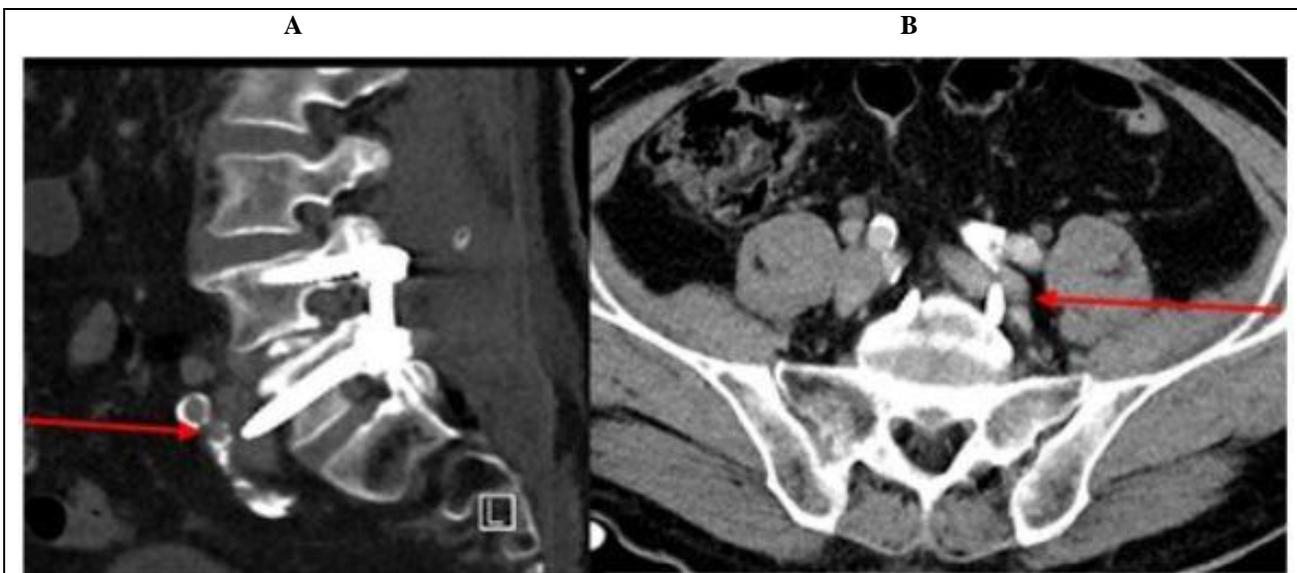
(A): Sagittal CT scan of the lumbar spine: The tip of the left L5 screw seems to be within the left common iliac vein (red arrow). No visible vascular lesion with leakage or haematoma; (B): Transversal CT scan of the lumbar spine: The tip of the left L5 screw seems to be within the left common iliac vein (red arrow). No visible vascular lesion with leakage or haematoma.
